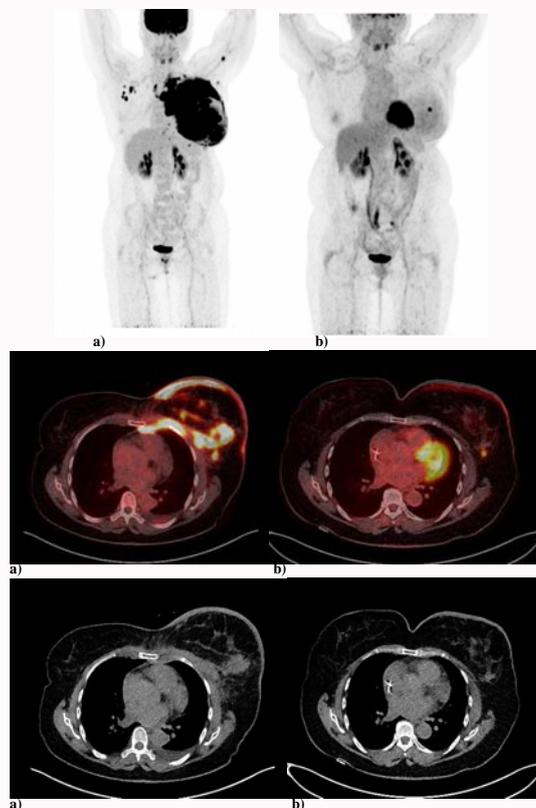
65 yr/Female. Breast cancer with both measurable and non-measurable disease. PET/CT images obtained at baseline (a) and follow up after treatment (b): Shows multiple FDG avid lesion in left breast and left anterior chest wall on baseline. Follow up images show partial response on RECIST 1.1 and partial metabolic response on PERCIST 1.0
